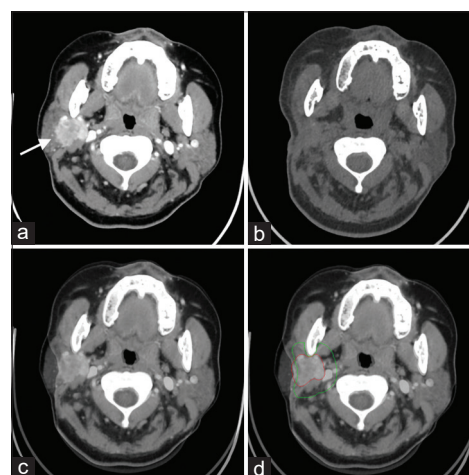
Delineation with the image fusion technique. (a) Preoperative CT images, the site of the tumor and the borders can be determined accurately. (b) Postoperative CT images, the tumor has been removed already, the original structure of the gland has changed and postoperative CT does not depict a clear outline of the tumor bed. (c) Align the preoperative image against the postoperative image via rigid registration of the bony anatomy. (d) One of radiation oncologists contoured GTV on the fused images, then CTV was obtained by automatically adding a 1 cm margin around the GTV. CTV was later manually revised based on the anatomical barriers
